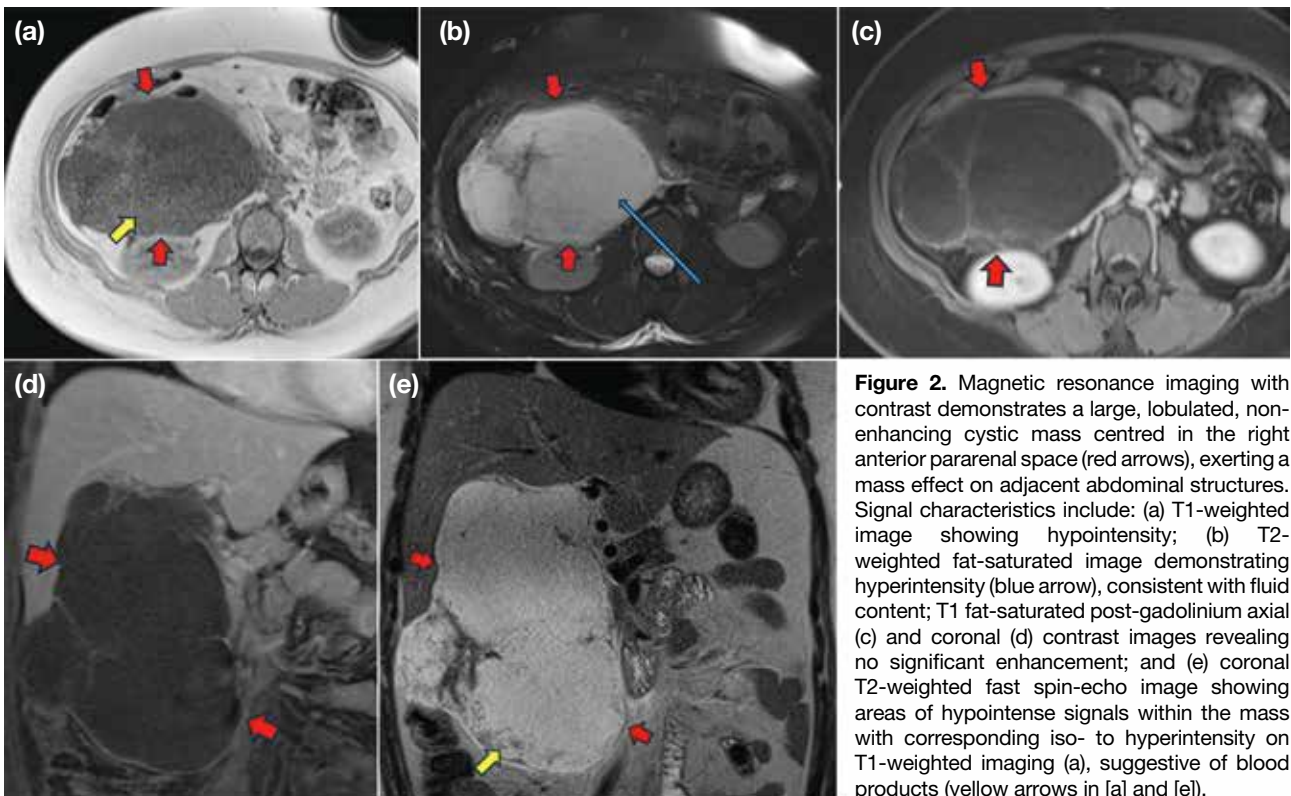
Magnetic resonance imaging with contrast demonstrates a large, lobulated, non-enhancing cystic mass centred in the right anterior pararenal space (red arrows), exerting a mass effect on adjacent abdominal structures. Signal characteristics include: (a) T1-weighted image showing hypointensity; (b) T2-weighted fat-saturated image demonstrating hyperintensity (blue arrow), consistent with fluid content; T1 fat-saturated post-gadolinium axial (c) and coronal (d) contrast images revealing no significant enhancement; and (e) coronal T2-weighted fast spin-echo image showing areas of hypointense signals within the mass with corresponding iso- to hyperintensity on T1-weighted imaging (a), suggestive of blood products (yellow arrows in [a] and [e]).
